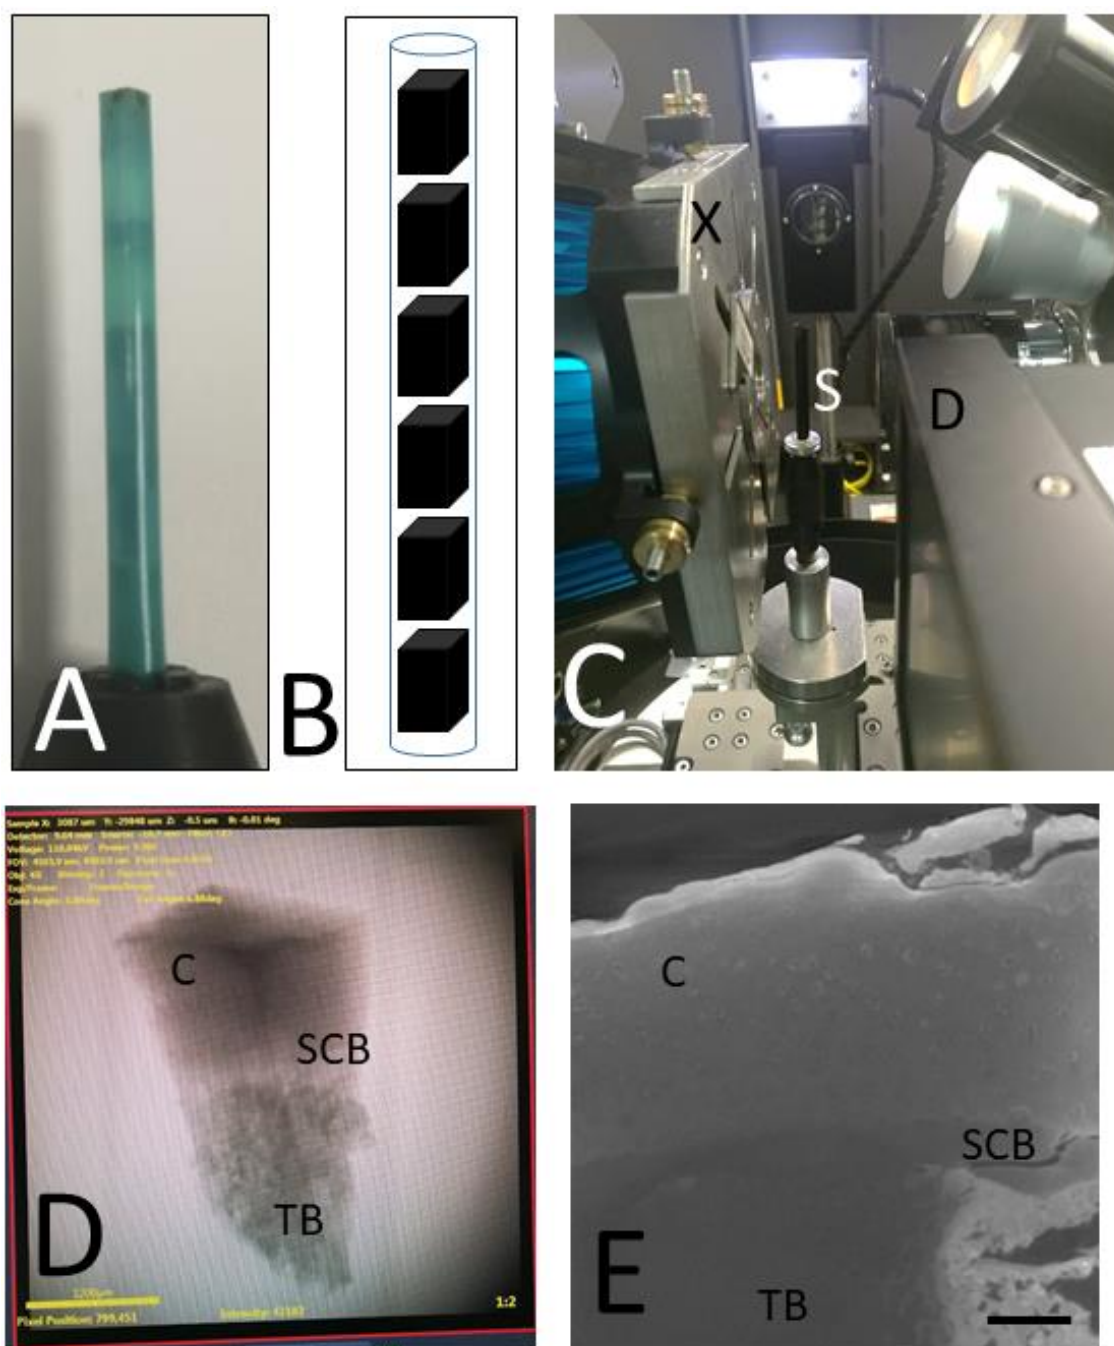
X-ray μ CT imaging
